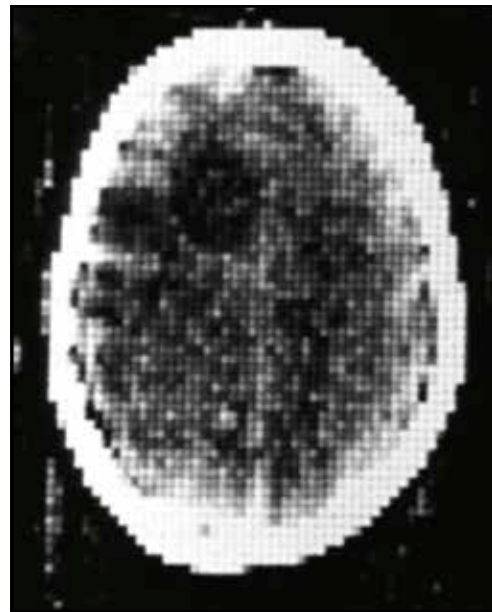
The first clinical computed tomography, performed in October 1971 at the Atkinson Morley Hospital in London (Taubmann et al.⁹).
